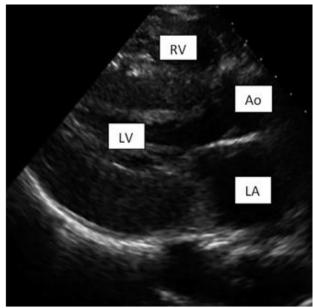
Echocardiographic images of the patient; left ventricular hypertrophy (LVH)
